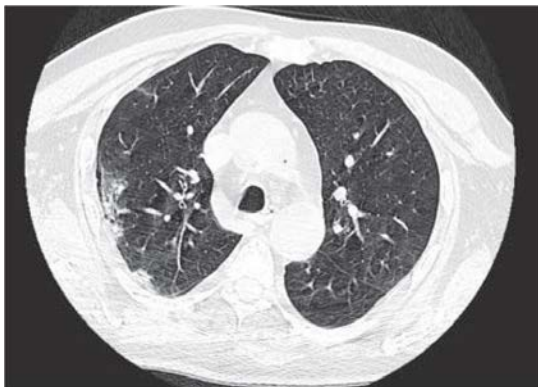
Multislice computed tomography of the chest before leaving the hospital: 5% lung tissue damage
